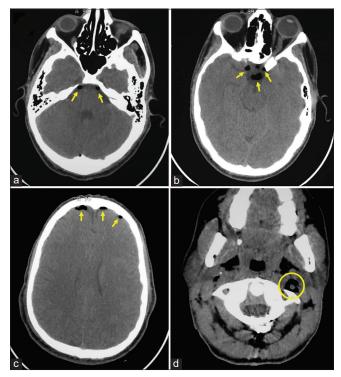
Axial cranial (a-c) and cervical C1 (d) computed tomography scan revealing mild pneumocephalus (arrows) at the prepontic cisterns (a), the sellar and laterosellar areas (especially next to the left optical channel) (b), and the bifrontal convexity (c). There is also a bilateral deep cervical emphysema and abnormal air in the left carotid sheath (d) (circle).
